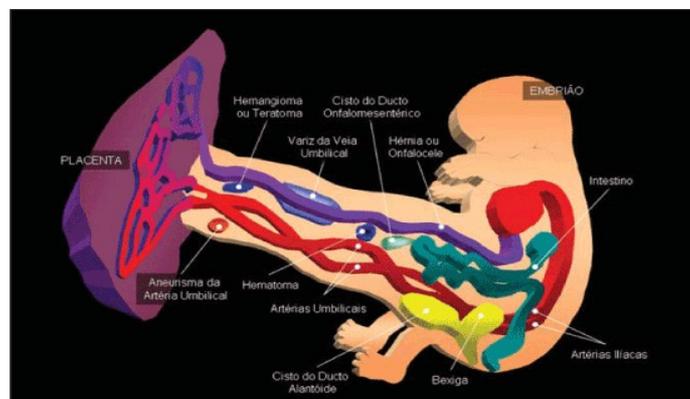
Umbilical cord masses. (Modified from: Callen PW, editor. *Ultra-sonografia em obstetria e ginecologia*. 4ª ed. Rio de Janeiro: Guanabara Koogan; 2002. p. 587).
